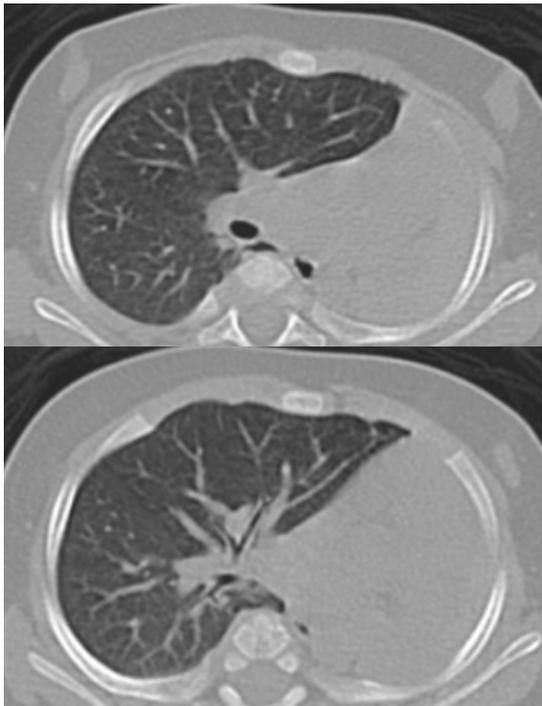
HRCT thorax showing absent left lung parenchyma with evident absence of left main pulmonary bronchus
